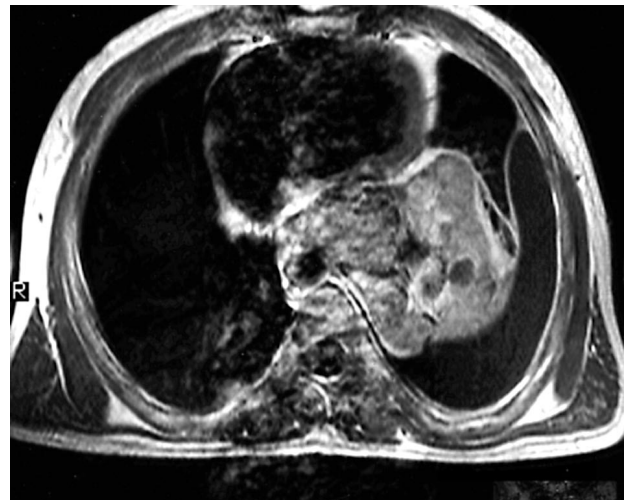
Pre-contrast T1-weighted MR image depicts a huge solid mass with inhomogeneous signal intensity, associated with ipsilateral pleural effusion. The mass displaces the heart anteriorly and the descending aorta laterally.
